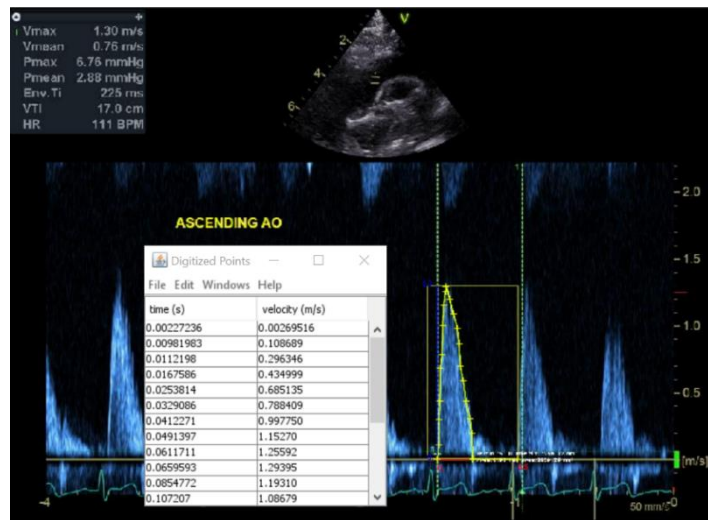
Example digitisation of the velocity data extracted from the doppler echocardiography study. The yellow crosshairs are manually placed and are joined by a straight line. The output data format which is exported to .csv is shown in the window.
